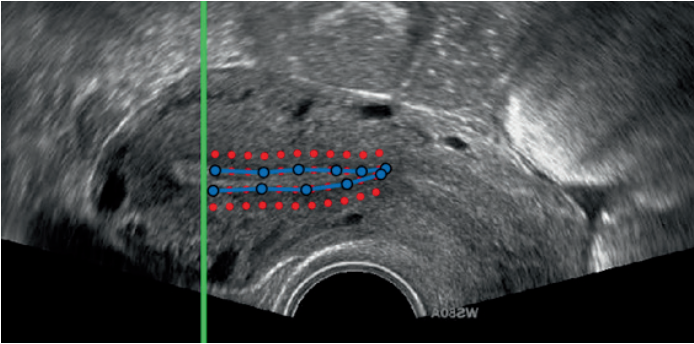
Ultrasound image of the uterus in the midsagittal section. Placement of the speckle tracking grid (red dots) along the endometrial border (blue line) at 5 mm (green line) from the apex of the fundus.
